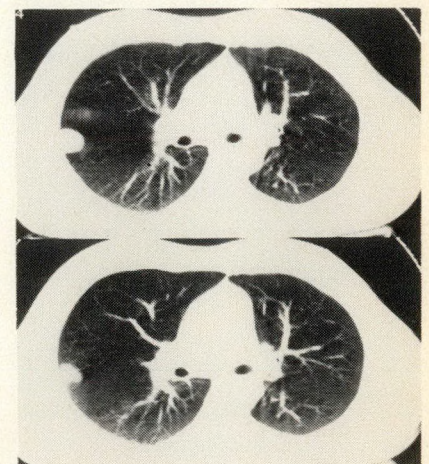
Preoperative staging studies of patient from Fig. 2 included computed tomography of chest revealing solitary chest metastasis.
